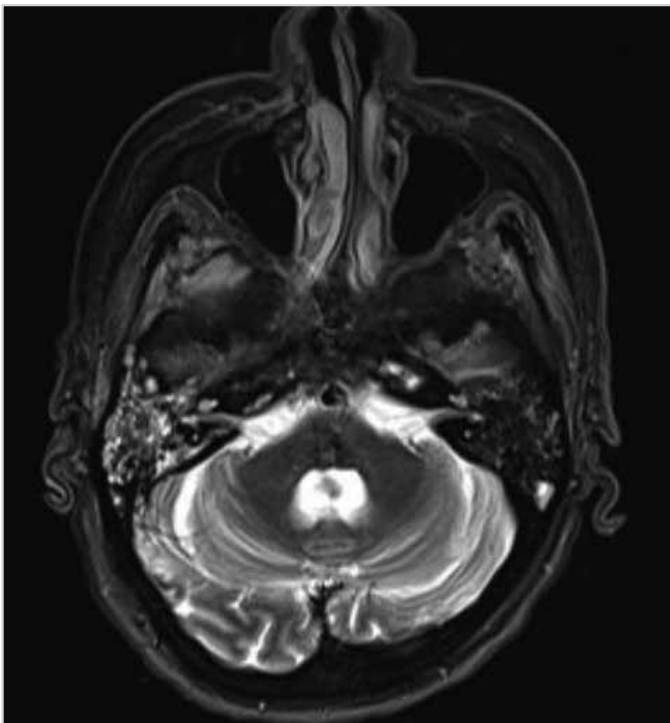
Magnetic resonance imaging view of the patient with bilateral malignant otitis externa
